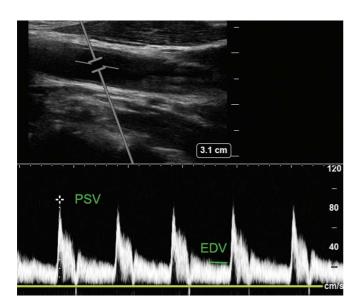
Ultrasound image of a patient with normal internal carotid artery with peak systolic velocity (PSV) less than 125 cm/second and end diastolic velocity (EDV) less than 40 cm/s.
